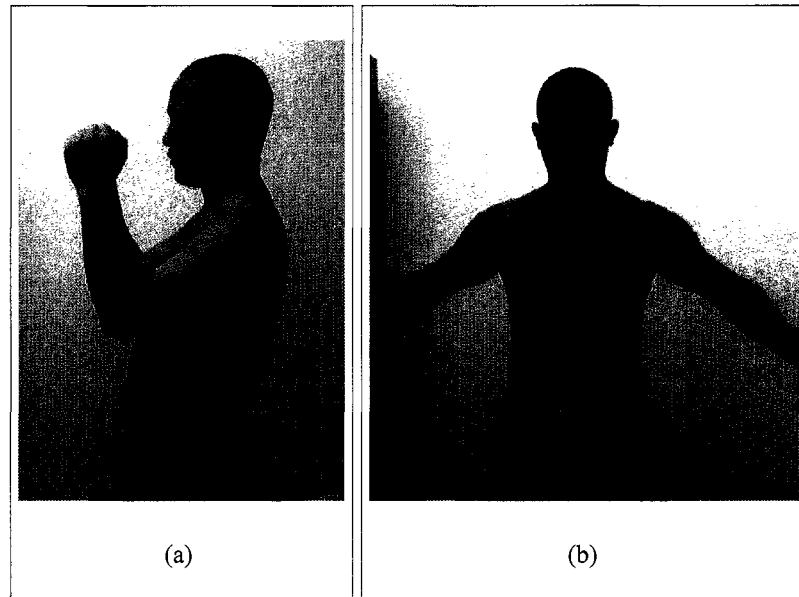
Different postures for acquiring the internal and external models. (a): optimal posture for the internal bone model using Multiple X-ray images; (b): optimal posture for the external trunk skin surface model using Inspeck 3D cameras.
